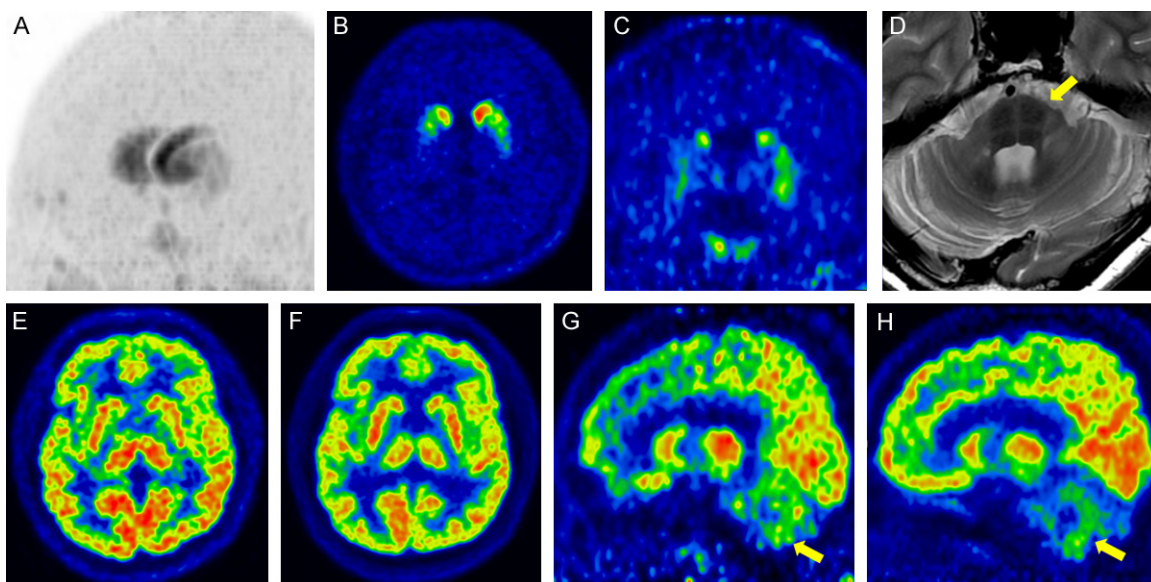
Multiple systemic atrophy with predominant cerebellar ataxia (MSA-C) (A) Maximum intensity projection image of DAT image using ^{18}F -FP-CIT showing decreased tracer uptake in the posterior putamen and ventral putamen, and relative preservation of the caudate nucleus. (B) Transaxial and (C) coronal DAT images showing decreased uptake in the dorsal and ventral putamen and loss of the ventrodorsal gradient. (D) Transaxial T2 MRI showing atrophic changes in the cerebellum and pons (“hot-cross bun sign”, yellow arrow). (E) Transaxial early perfusion image of ^{18}F -FP-CIT and (F) glucose metabolism of ^{18}F -FDG showing no abnormality in the striatum. (G) Sagittal early perfusion imaging of ^{18}F -FP-CIT and (H) glucose metabolism of ^{18}F -FDG showing decreased perfusion and glucose hypometabolism in the cerebellum.
